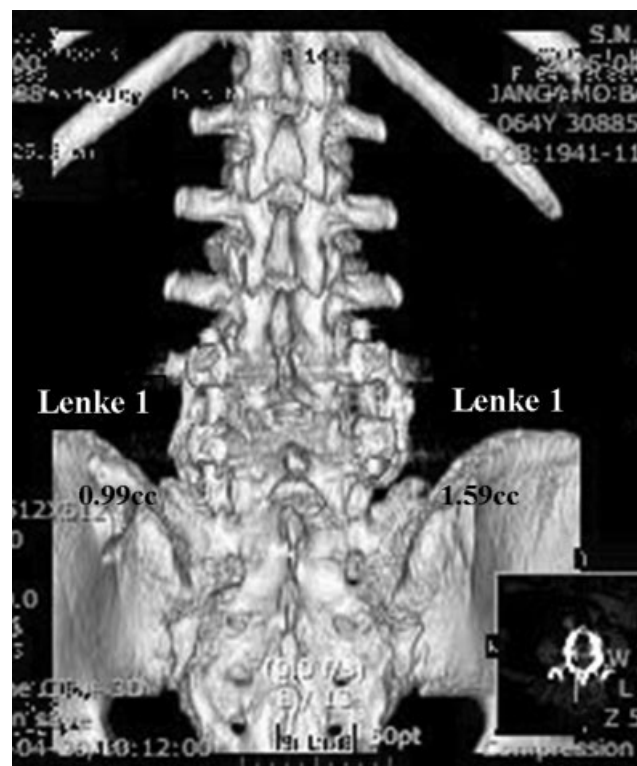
3D thin cut (1 mm) CT images with axial, sagittal, and coronal reconstructions were obtained 12 months after surgery.
